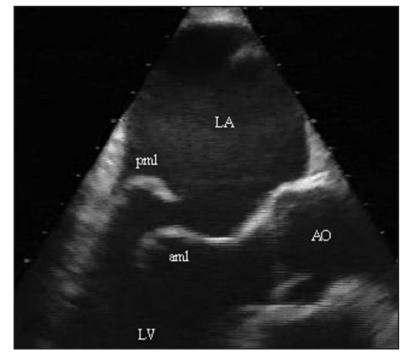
Transoesophageal (TEE) frame of a flail posterior mitral leaflet (P2).
